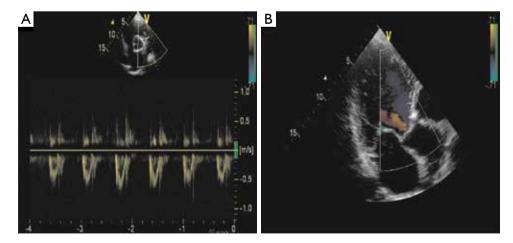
2D-heart ultrasound showed a diffuse hypokinesia of the left ventricle with a mild mitral regurgitation and a moderate reduction fraction (40.2%).
